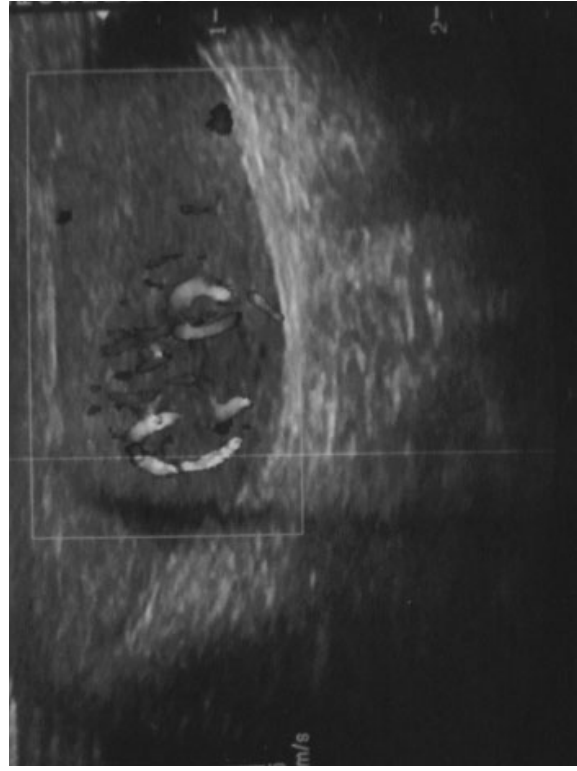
Doppler US show hypervascularity in the tumoral lesion.
